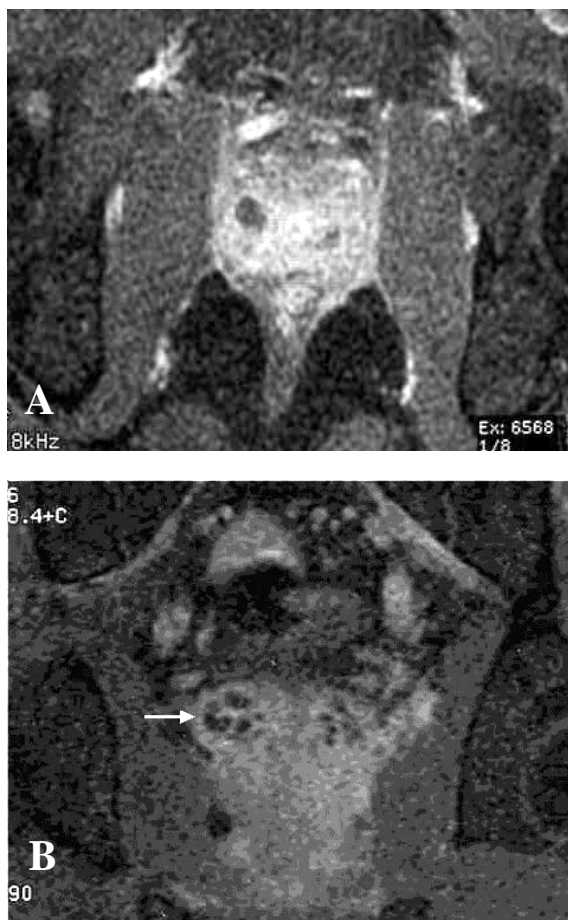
HIV-positive patient (41 years old), MRI T1-weighted FSE (A) axial scan, two small abscesses in right CG and left PG, diffused heterogeneous enhancement in the rest of gland representing prostatitis (B) coronal scan, thickened enhancing wall of seminal vesicles representing seminal vesiculitis (arrow)
